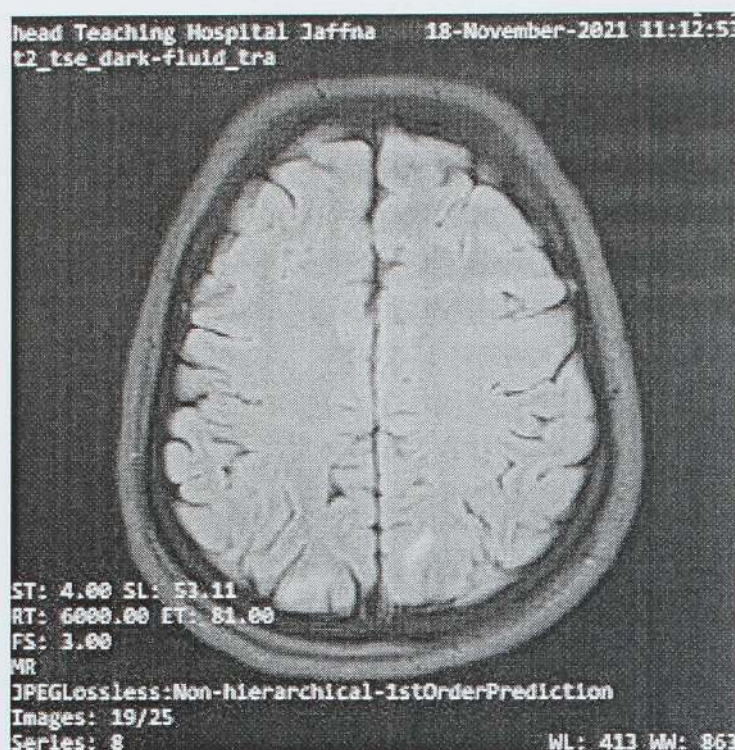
MRI Brain showed high signal intensities on T2, FLAIR images in parieto-occipital regions bilaterally
